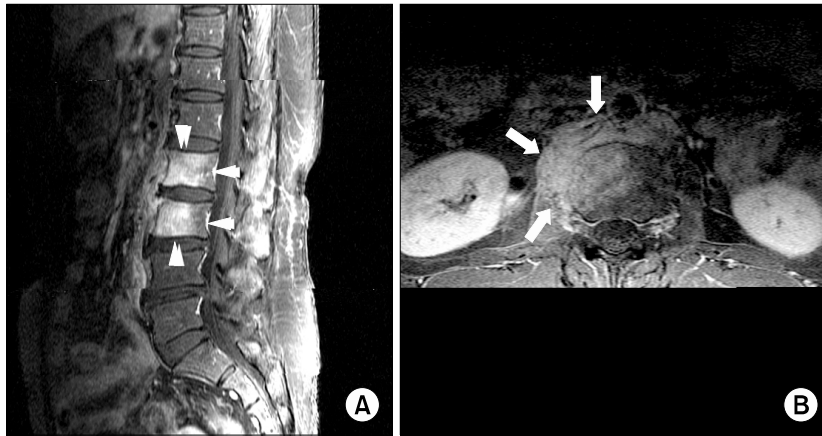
Sagittal (A) and axial (B) post-contrast T1-weighted MR images show diffuse bone marrow enhancement (white arrow heads) in the L2 and L3 vertebral bodies along with paravertebral soft tissue thickening and enhancement (white arrows). Note the relative sparing of the intervertebral disc spaces.
